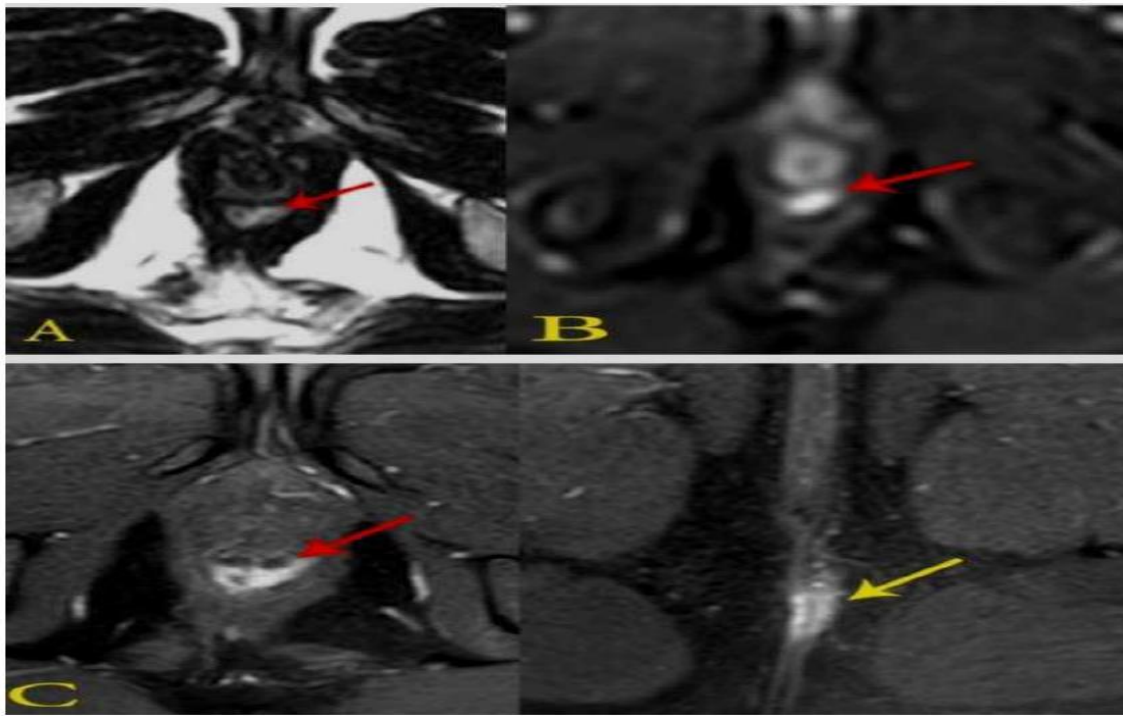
A male patient aged 56 years old with perianal discharge and pruritus. a) Axial T2-WI: shows hyperintense intersphincteric fistula with focal distension forming small abscess with low SI gas foci inside from 5 to 7 o'clock (arrow). b) Axial DWI: shows restricted diffusion (hyper intensity) at the intersphincteric abscess (arrow).c) Axial fat-suppressed T1+C: enhanced fistulous tract from left natal cleft (yellow arrow) with intersphincteric abscess from 5 to 7 o'clock with gas bubbles inside (red arrow). Overall MRI finding consistent with horseshoe intersphincteric fistula with small abscess (Grade II).
